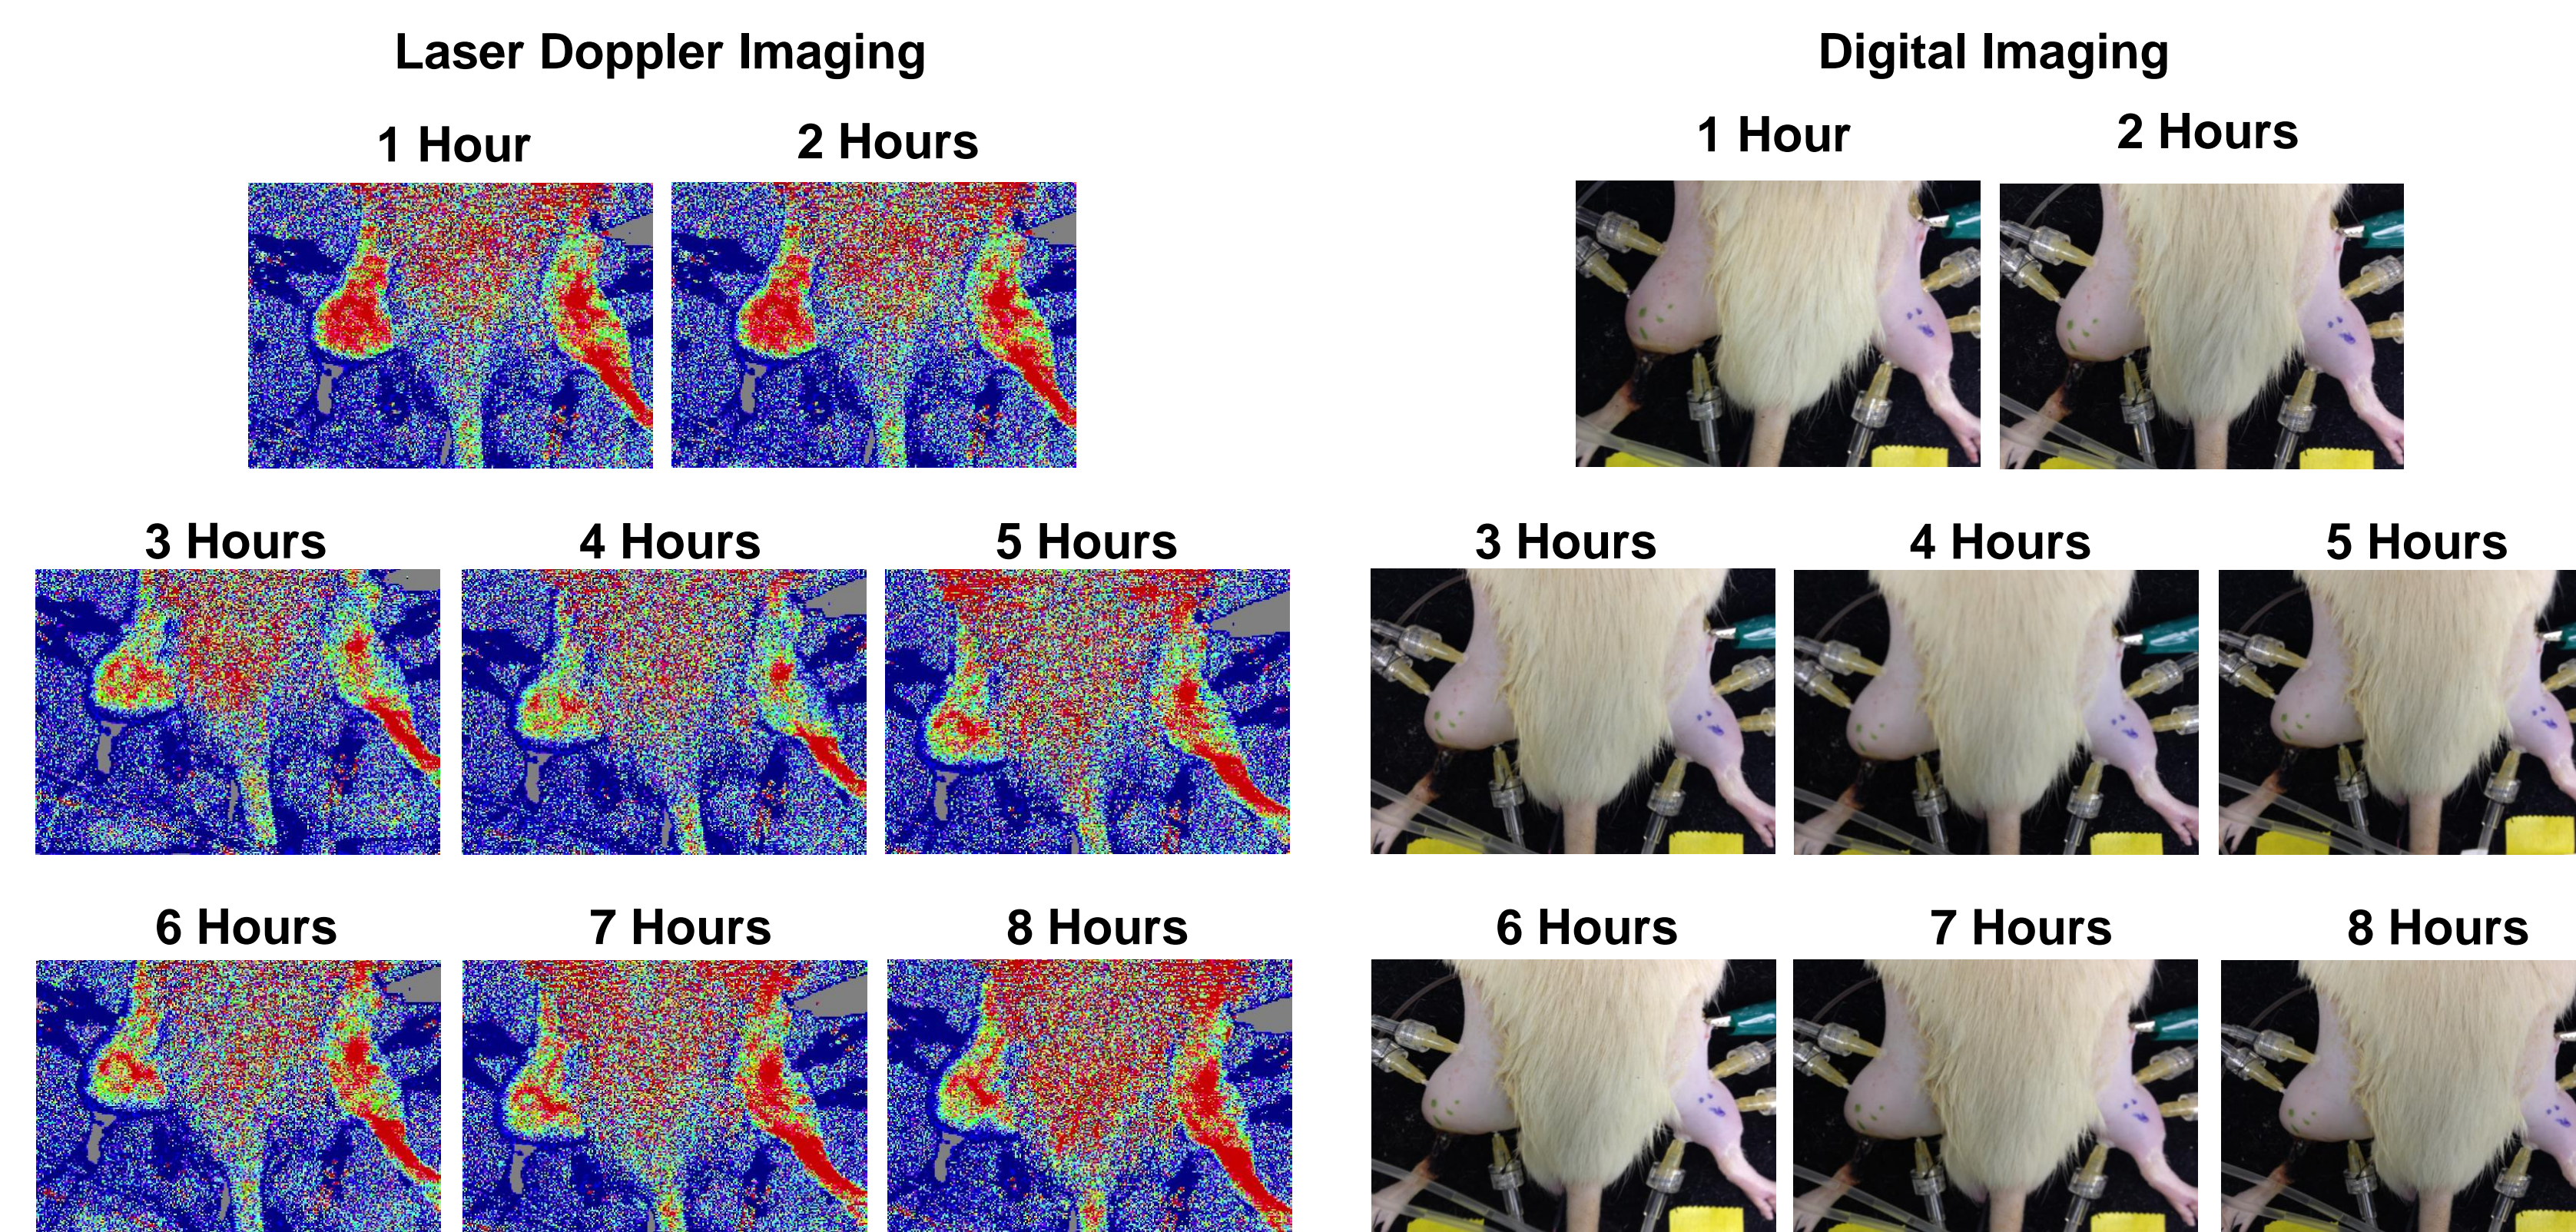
Laser Doppler digital images of electrically injured and control hindlimbs
